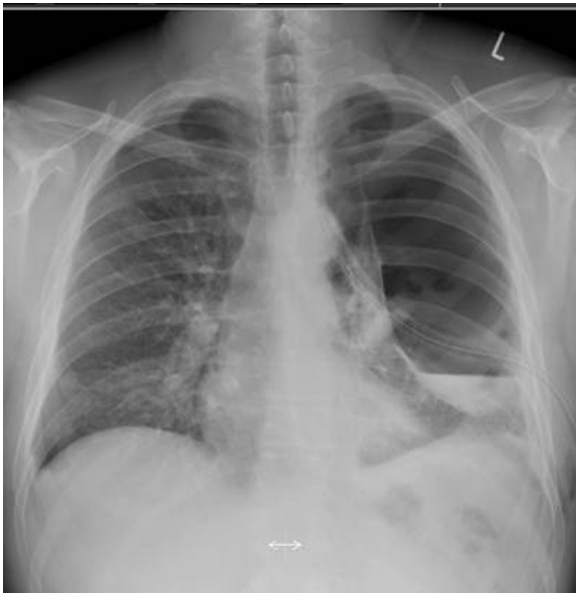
PA chest radiograph showing a left sided pneumothorax and empyema with chest drain in situ.
